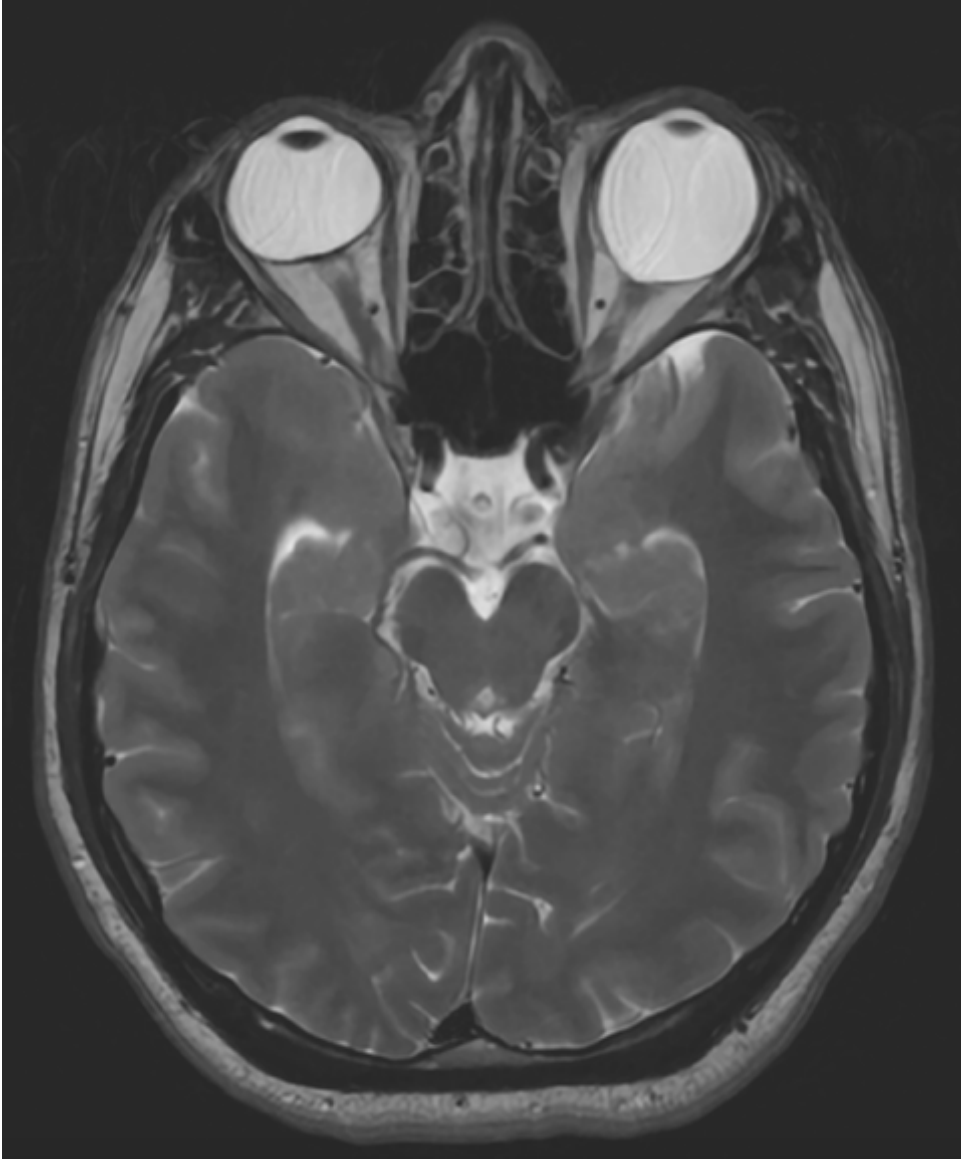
Axial T2-weighted magnetic resonance imaging scan showing significant axial elongation of the left eye (32.05 mm) compared to the right eye (25.61 mm), consistent with high axial myopia.
